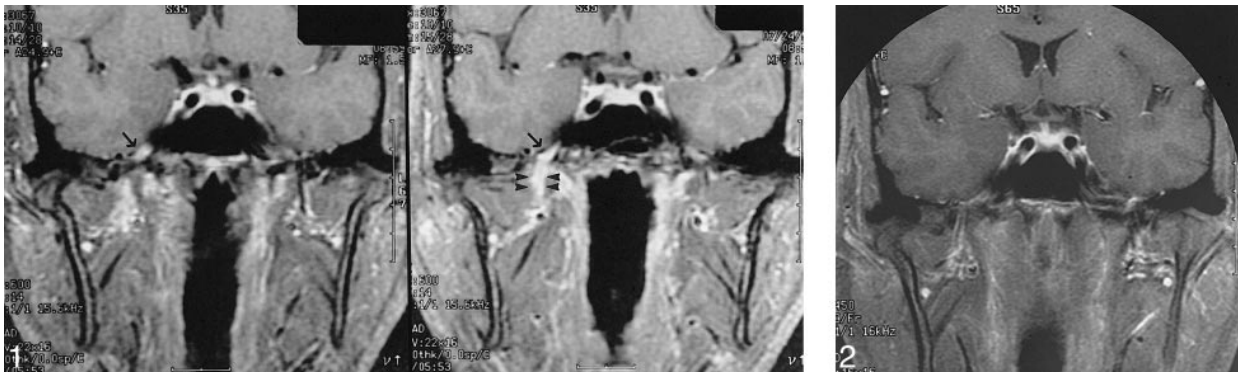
MR images of a 38-year-old man with numbness in the distribution of the mandibular division of the right trigeminal nerve, which occurred after a scalding injury to his tongue. Coronal high-resolution fat-suppressed, contrast-enhanced T1-weighted (600/15/2 [TR/TE/excitations]) MR images, obtained at the time of presentation, show striking enhancement and thickening of the mandibular nerve (V3) at the foramen ovale (arrow) and upper masticator space (arrowheads) on the right.
